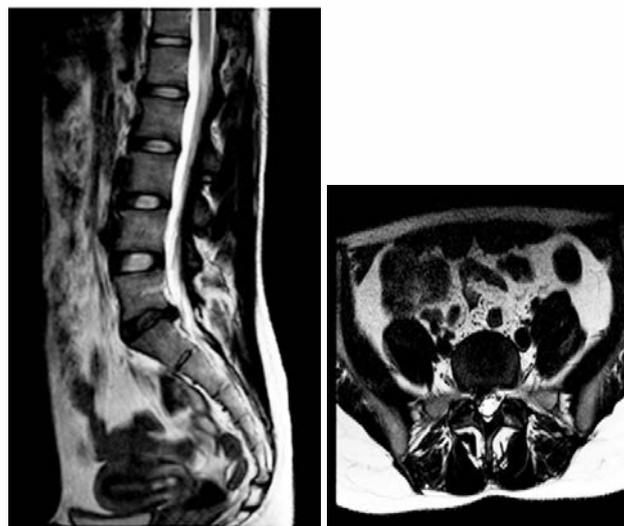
Preoperative MRI-grams of lumbosacral spine: (A) – sagittal section; (B) – axial section, MRI-gram of lumbar spine (herniated intervertebral disc L<sub>V</sub>-S<sub>1</sub> is marked by arrow)
